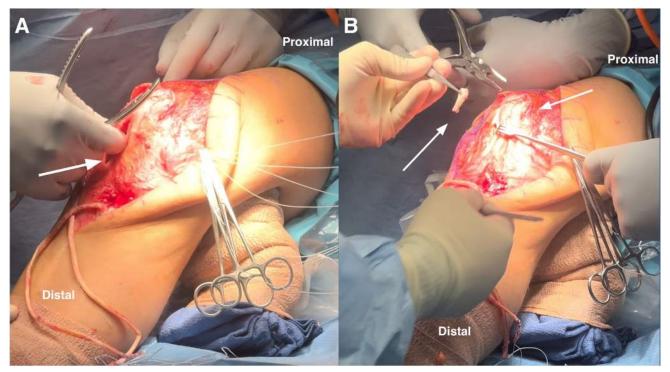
Right knee anterior midline approach with the patient in supine position. The patellar tendinopathy is addressed with a vertical incision made at the central aspect of the tendon (A), and the pathologic portion is identified and debrided (white arrow) (B). A rongeur is used at the inferior pole of the patella to remove excessive scarring. In agreement with our previous clinical indications, confirmation of the radiograph assessment >60% of the patellar tendon is detached.
